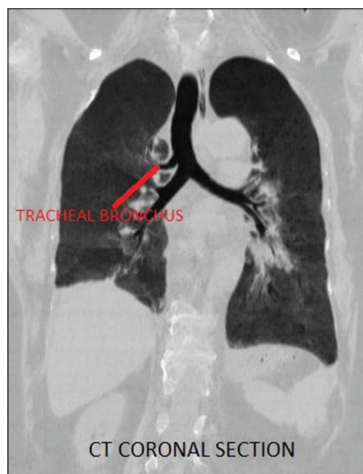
CT scan: thorax coronal section
